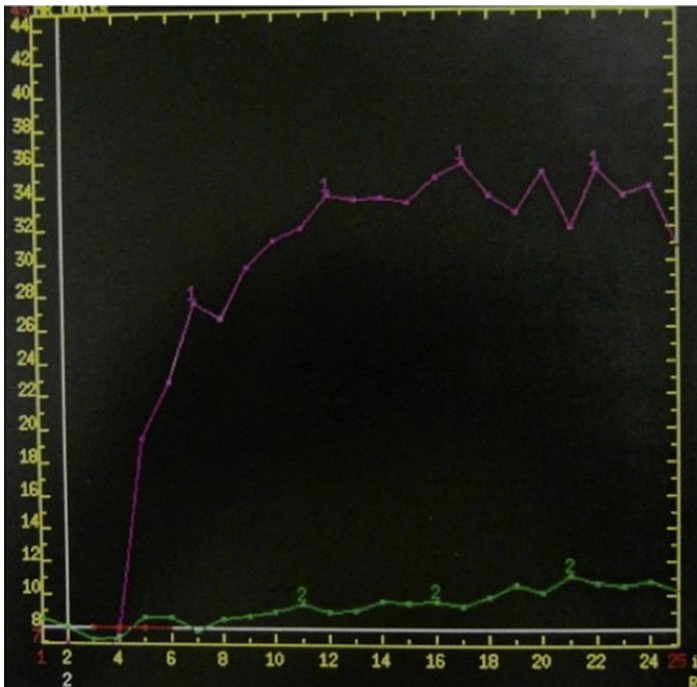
Same case as Fig. 6. The high temporal resolution of this DCE-MR imaging technique allows derivation of accurate time-intensity curves.
